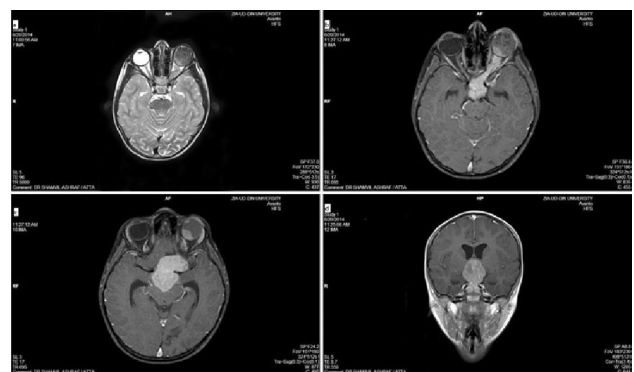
MRI brain and orbit of 4 years old female patient showing left eye retinoblastoma with optic nerve and suprasellar extension. a. T2W axial b,c & d. Post gadolinium T1W axial and sagittal images. Intensely enhancing left globe mass noted causing its enlargement. Left optic nerve and optic chiasm is markedly thickened and enhancing represents infiltration by the tumor. MRI brain shows large sellar and suprasellar mass representing intracranial extension of the primary tumor which is causing obstructive hydrocephalus. Normal right globe and optic nerve.
